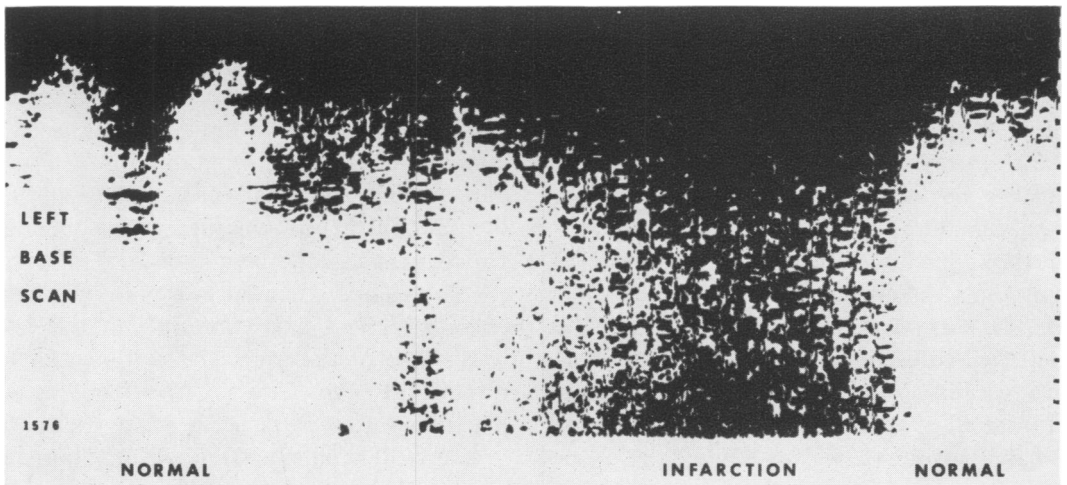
Tracing taken with the compound, or B-scanner. Depth of penetration of the beam is read in the vertical axis, from top to bottom. The patient was a 54-year-old man with aortic stenosis, aortic insufficiency, and mitral insufficiency, who developed severe pleuritic left chest pain and hemoptysis while under treatment for cardiac decompensation. An I_{131} -MAA scan revealed decreased isotope concentration in the right apex with no abnormal areas seen in the left lung. The ultrasound pattern disclosed two areas of apparent pulmonary infarction in the left lower lung field. As shown above, the scanning path entered one of these areas of infarction from the left, moved across the area of infarction, and then passed into normal lung to the right of the scan. The patient had a cardiac arrest from which he could not be resuscitated. At necropsy, the right lung was normal but occlusive emboli were found associated with recent infarcts in the left lower lobe. The location of the lesions corresponded with that anticipated from the ultrasound recordings.
